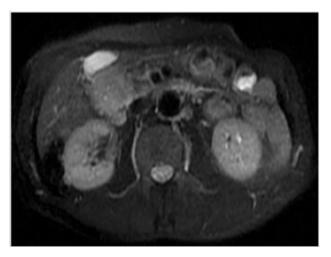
Axial T2-weighted image demonstrating soft tissue mass of slightly high signal intensity at the head of pancreas.
